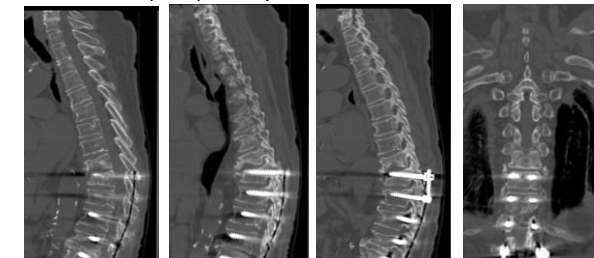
Sagittal images (right three) and Coronal (left) on CT Thoracic spine showing T10 compression fracture with hardware.
